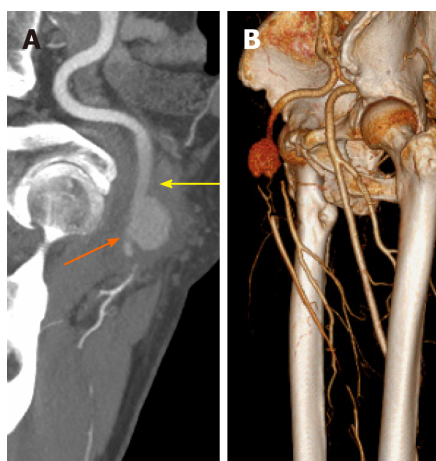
Preoperative computed tomography angiography. A: A pseudoaneurysm of the common femoral artery compressed its distal outflow tract (orange arrow); B: Occlusion of the superficial femoral artery and deep femoral artery.
